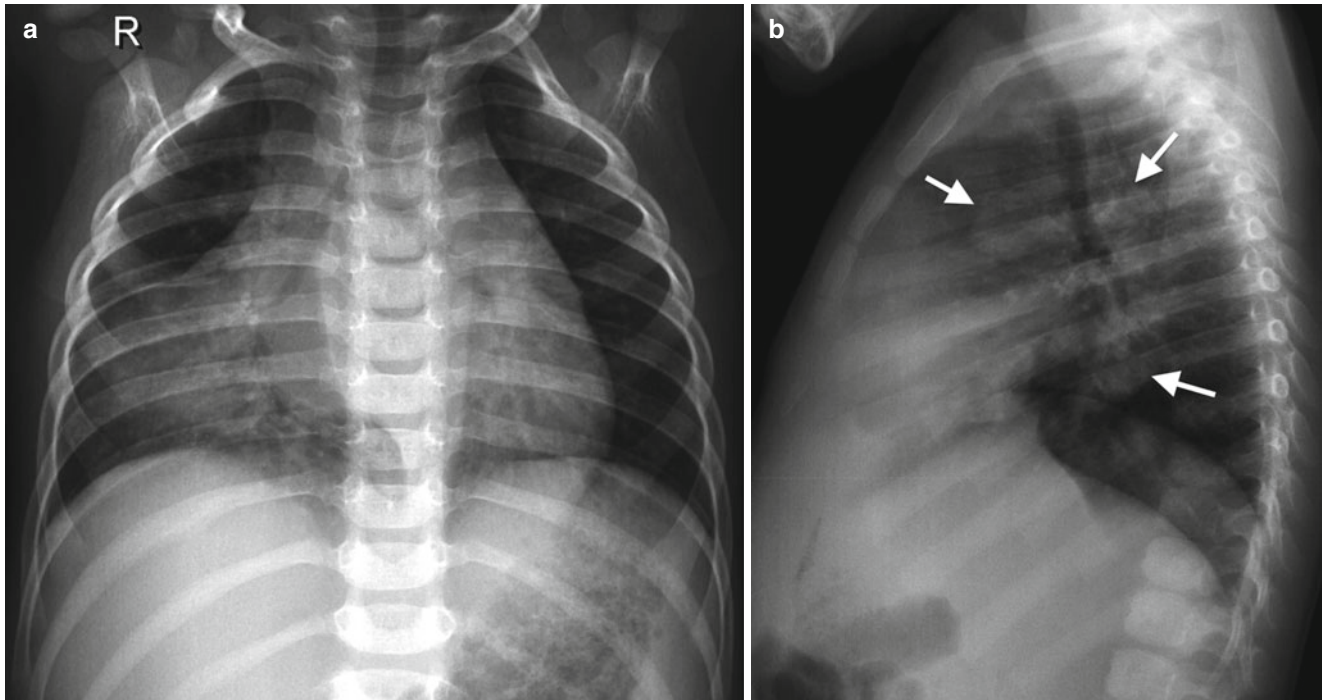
Primary TB disease. Chest radiographs of a 2-year-old girl with chronic cough and fever showing dense right middle lobe consolidation on the frontal view (a) and extensive lymphadenopathy (*white arrows*) on the lateral view (b)
